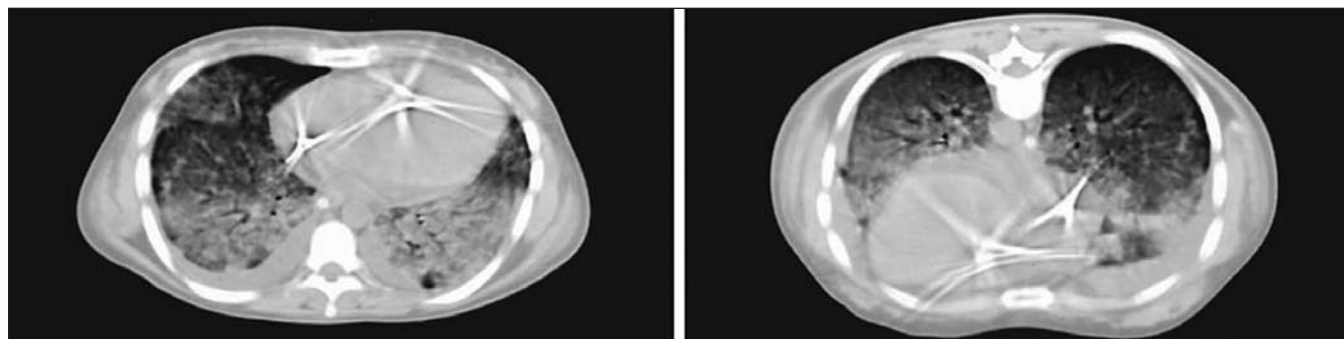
Computed tomography scan of the lungs showing acute respiratory distress syndrome when the patient is lying supine (left) and prone (right). Note the density redistribution in the prone compared with the supine position.
